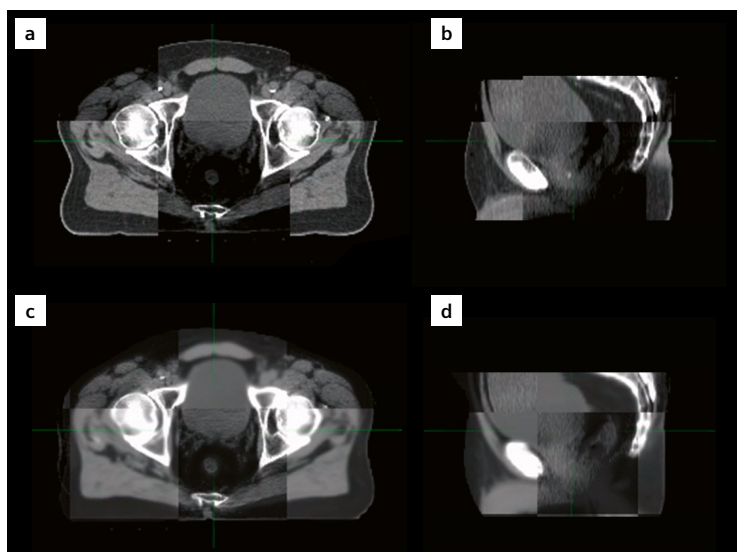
Localization accuracy comparison using the original planning CT data to CBCT registration as the reference (a, b), versus CBCT registration to the MR-based Synthetic CT (c, d).
